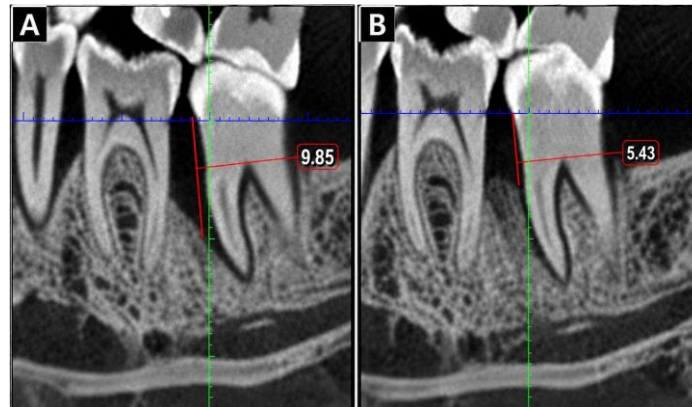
Representative CBCT images showing baseline defect morphology prior to surgery (a) and radiographic bone fill following regenerative periodontal therapy (b).
